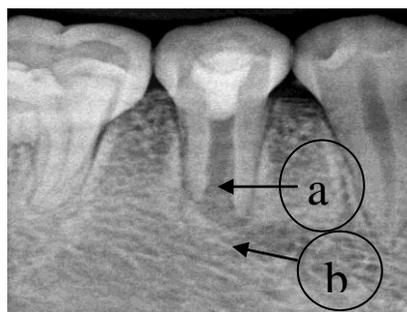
2 years postoperative view of 45 indicating thickening of lateral dentinal wall (a) and almost complete resolution of periapical lesion in relation to the tooth (b).
